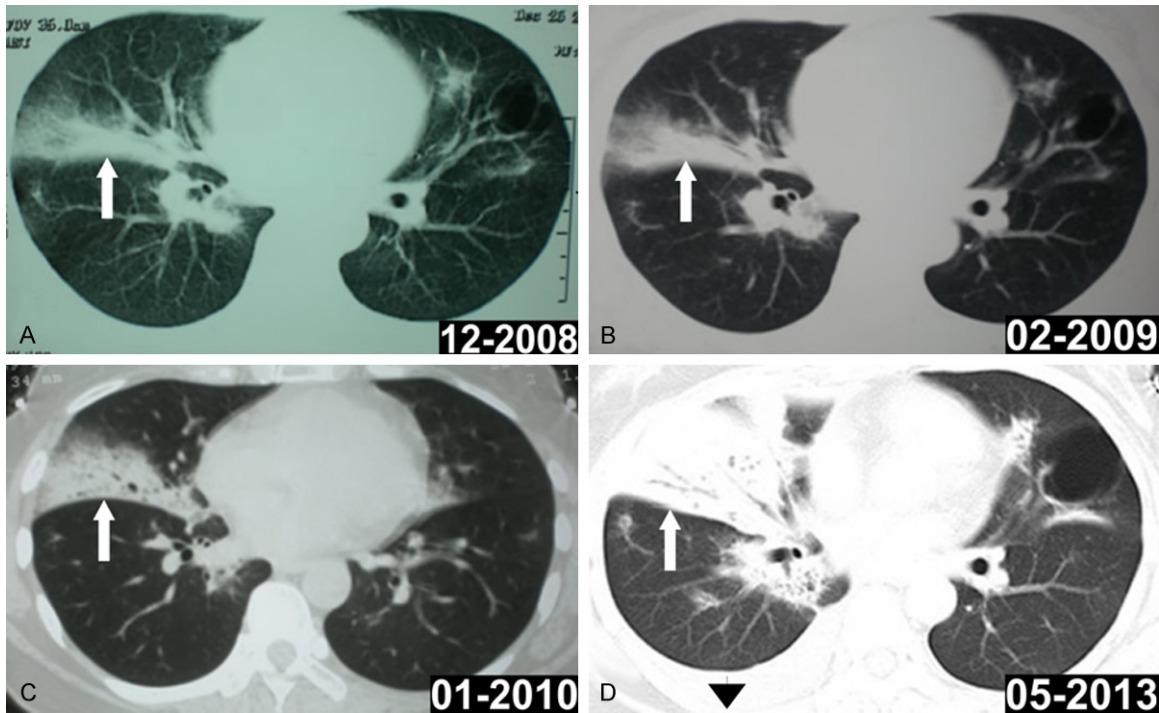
CT scans of nearly the same section of chest from 2008–2013 showed lesions and consolidation with signs of air bronchogram in the middle lobe of the right lung (A→D, white arrow). Right pleural effusion can be seen (D, black arrowhead).
